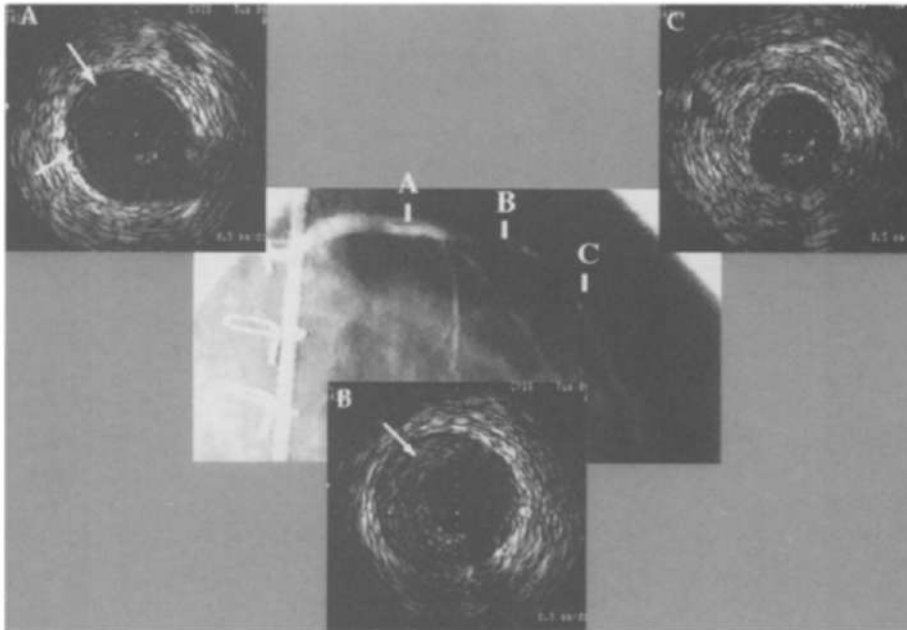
Longitudinally nonuniform pattern of intimal thickening. Intracoronary ultrasound images (lettered, small panels) from three segments indicated on contrast coronary angiogram (corresponding letters, central large panel): A, site in more proximal segment; B, site in middle segment; C, site in more distal segment). Black circle in center (calibration dots at intervals of 0.5 mm) of each ultrasound image is imaging catheter. Circular lumen is slightly less black. Soft gray shadow of intimal thickening (small arrows) is outlined by darker stripe of more echolucent medial layer in panels A and B. Intimal thickening is severe (Figure 2) in segments A and B, but there is little or no thickening of intima in vessel segment in C. This is classified as longitudinally nonuniform pattern of intimal thickening.
